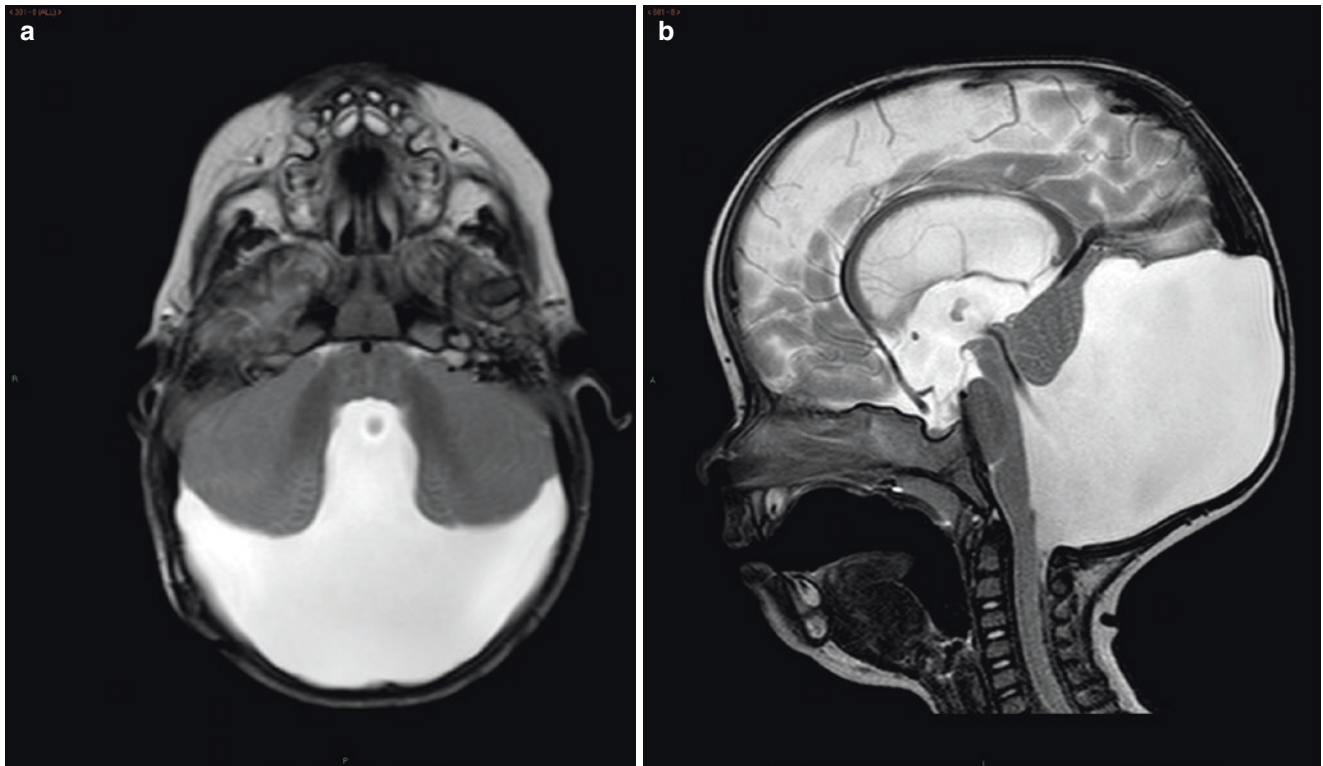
Dandy-Walker malformation. Axial T2-weighted (a) and sagittal T2-weighted (b) MR images show a dilated fourth ventricle extending posteriorly to fill the posterior cranial fossa, which is
